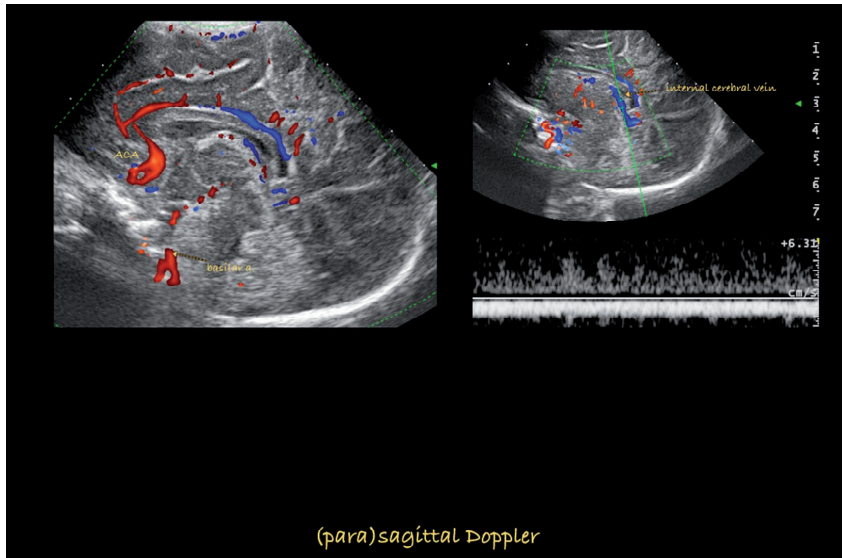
(Para)sagittal Doppler
